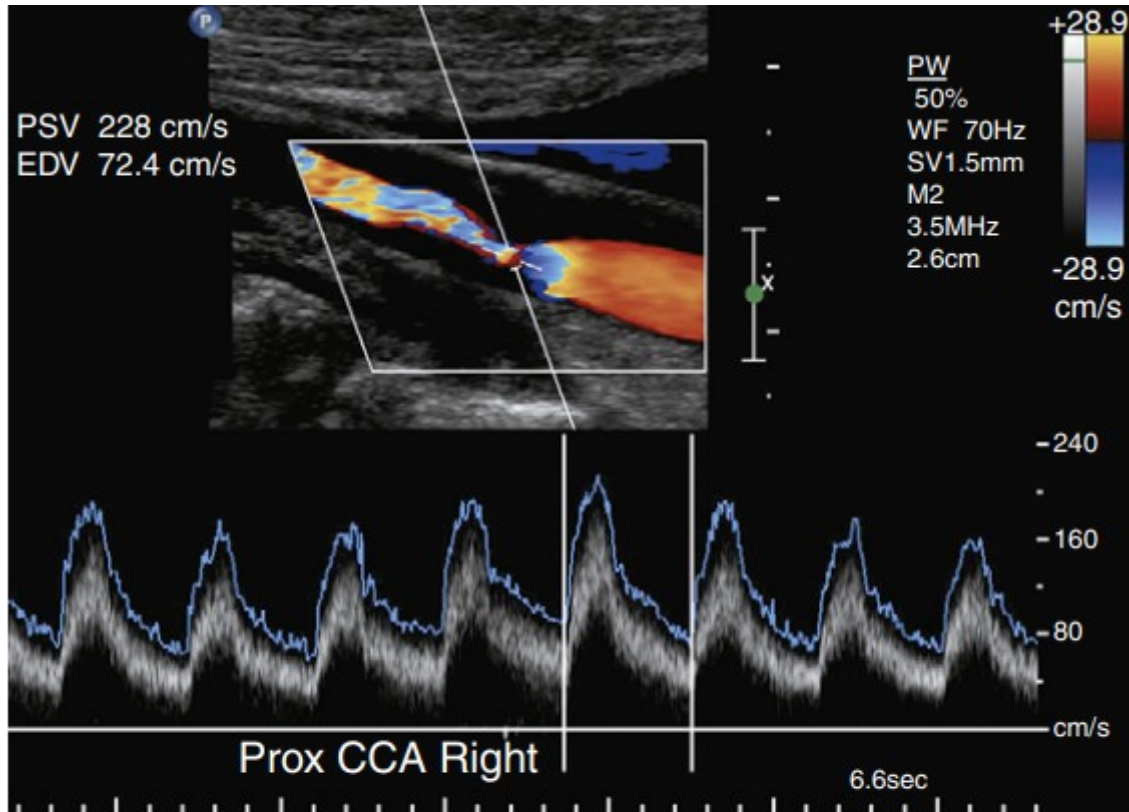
Hypoechoic (echolucent) plaque causing a significant internal carotid artery stenosis. Note the Doppler velocity tracing with a narrow spectral window, indicating that the sample site is at the point of maximal narrowing.
